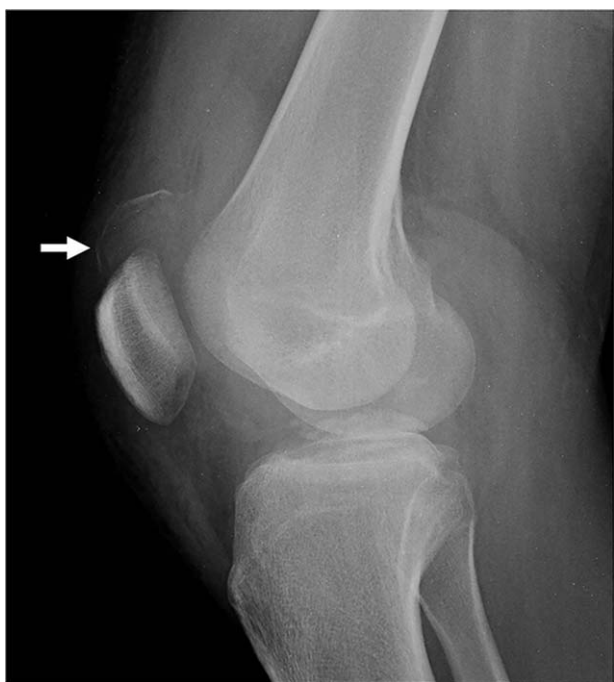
A 19-year-old female with sleeve fracture at the superior pole of the left patella. Patella and avulsed fragment are showed in plain radiograph (arrows).
